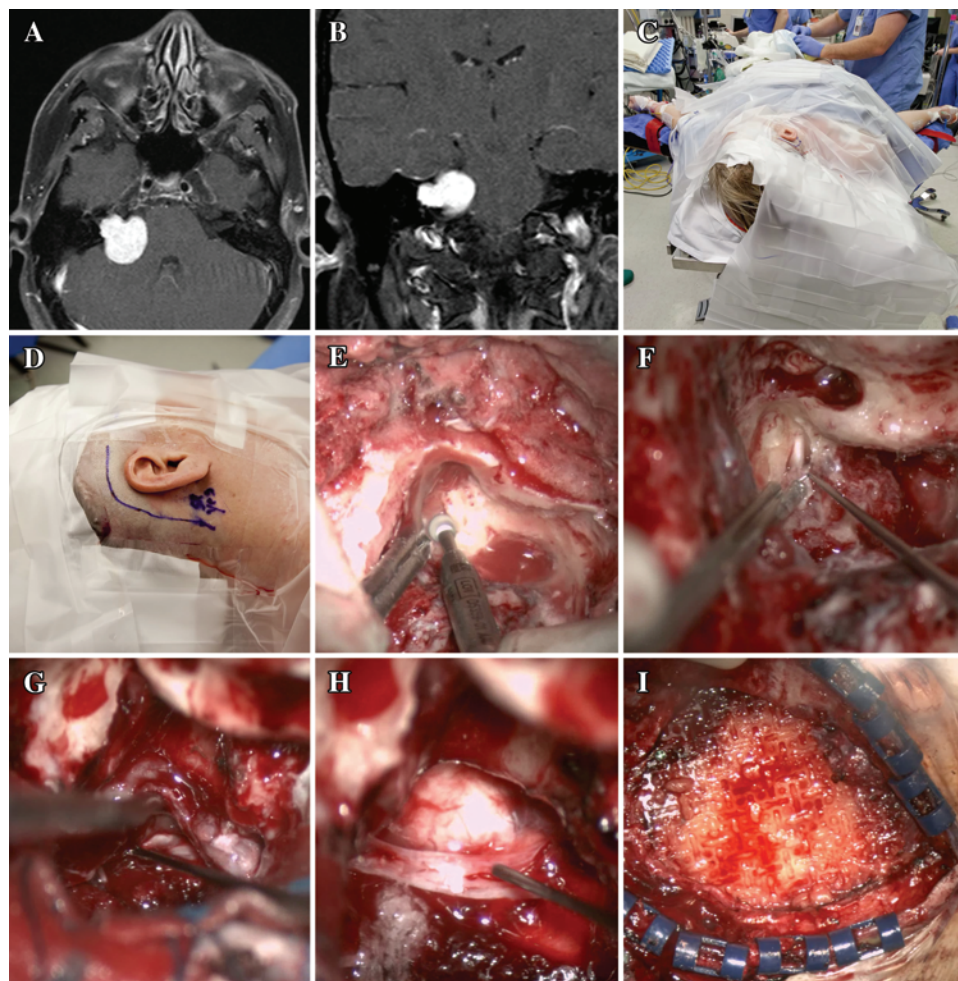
Axial (A) and coronal (B) T1-weighted MRI studies obtained with contrast enhancement of the brain showing a VS occupying the right CPA and extending into the IAC of a 42-year-old woman who presented with a history of hearing loss in the right ear. C–I: Intraoperative photographs obtained during the translabyrinthine approach to the tumor. C: The patient is positioned supine, and her head is rotated to the contralateral side. D: A hockey stick-shaped retroauricular skin incision extending behind the mastoid tip is made. E: The mastoidectomy is performed with the high-speed drill. F: After the dura of the IAC is opened, the facial nerve is located and confirmed using stimulation. The vestibular nerves are cut, and the tumor is dissected from the facial nerve. G: The tumor is debulked with extracapsular dissection. The root entry zone of the facial nerve at the brainstem is identified and confirmed with stimulation, and then the tumor is gently reflected laterally and dissected from the facial nerve under direct visualization. H: After tumor removal, the facial nerve is stimulated at the root entry zone. I: Free abdominal fat is used to close the dural defect and occlude the mastoidectomy cavity. The bone defect is covered with a mesh implant.
